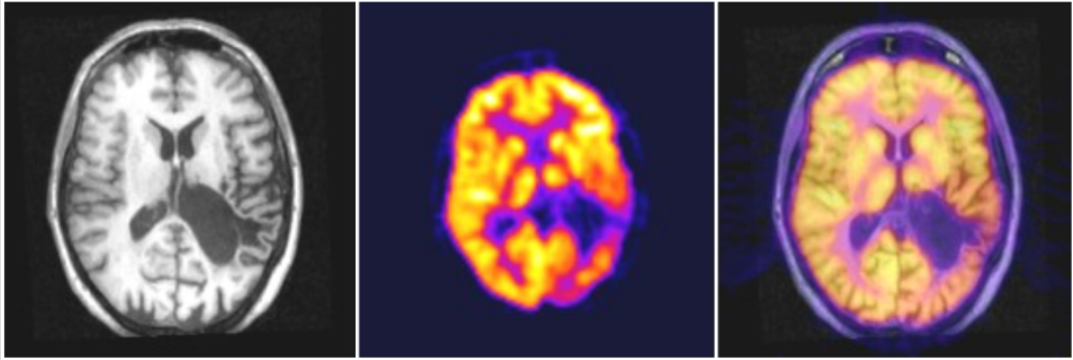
On the left, a axial slice of a brain MRI of a patient with periventricular leukomalacia. In the middle, an ^{18}F -FDG PET image of the same subject is shown. Brighter intensities represent high glucose uptake. On the right, automatic registration of both images showing functional-to-anatomical correspondence between images.
